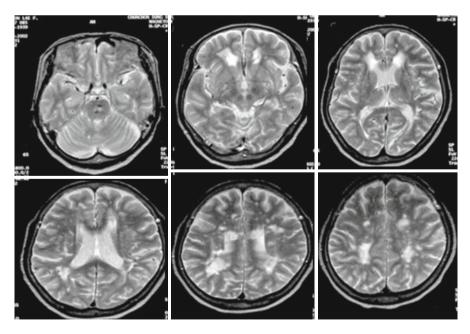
T2-weighted MRI shows multiple periventricular and white matter ischemic lesions
